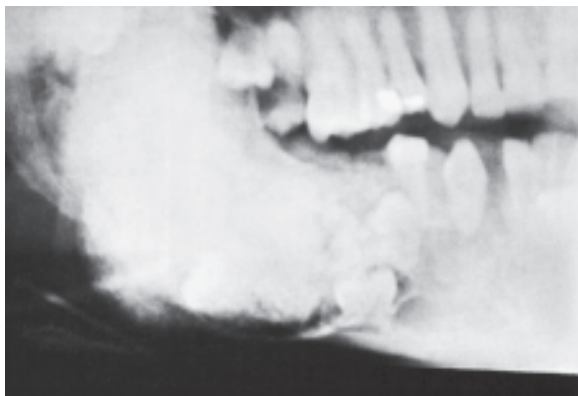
Typical radiographic picture of an ossifying fibroma showing well-demarcated radiolucent mixed radiopaque mass
